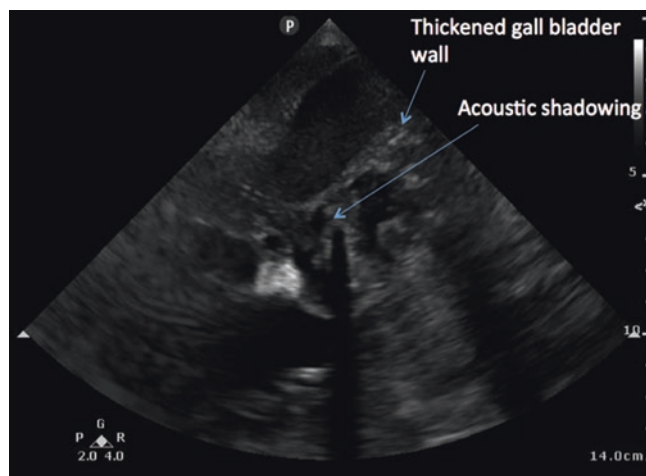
Bedside ultrasound for suspected biliary disease. A point-of-care ultrasound shows a distended gallbladder with a thickened wall (>3 mm) and distal acoustic shadowing which usually represents a stone in the neck of the gallbladder or the cystic duct. This patient was admitted with septic shock and gram-negative bacteremia. The most sensitive ultrasound finding in acute cholecystitis is the presence of cholelithiasis in combination with the sonographic Murphy sign (tenderness in the right hypochondrium) while performing sonography. Both gallbladder wall thickening (>3 mm) and pericholecystic fluid are secondary findings. Other less specific findings include gallbladder distension and sludge (best appreciated with Video 37.14)
